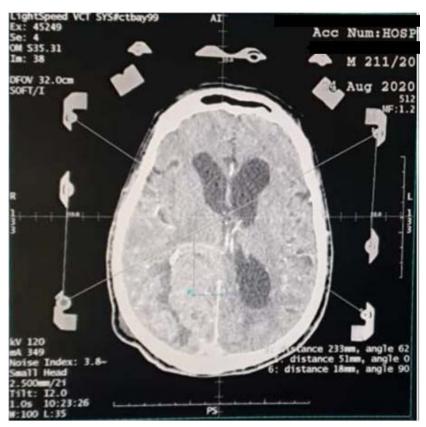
Axial section CT image showing a poorly defined hypodense right occipital tumour process that enhances after contrast injection
